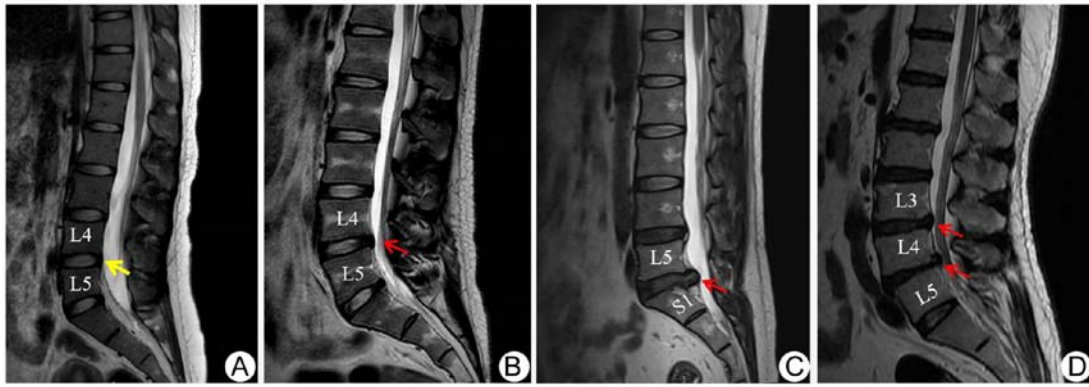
Magnetic resonance imaging Pfirrmann grading. (A) HD: L4-5 IVD of patient with Pfirrmann stage I. The IVD has a uniform high signal, and the NP and AF are clearly separated (yellow arrow). (B) Stage II patient: L4-5 IVD with horizontal low signal bands but a clear border between the NP and the AF (red arrow). (C) Stage III patient: L5-S1 IVD with a gray NP signal and an unclear boundary with the AF, but no significant change in height (red arrow). (D) Stage IV patient: L4-5 IVD with a gray NP signal, and a significantly reduced the height of the IVD (red arrow). IVD, intervertebral disc; NP, nucleus pulposus; AF, peripheral annulus fibrosus.
